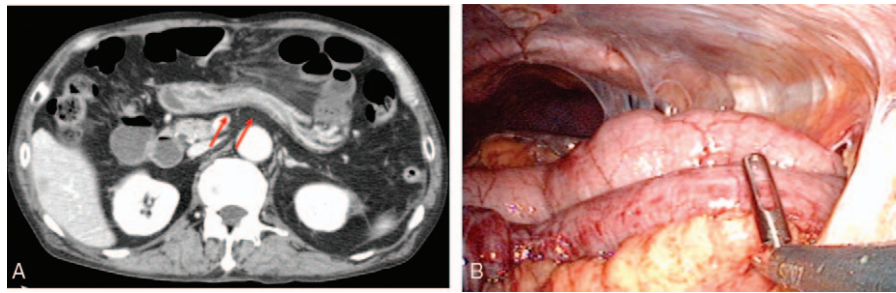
(A) Contrast CT image in Case 2. The closed loop obstruction was detected above the stomach, which had been crushed flat (red arrow). (B) Representative photograph of Case 2 during surgery. SPS clearly showed that a loop jejunum had herniated through an orifice due to adhesion of the greater omentum to the abdominal wall.
